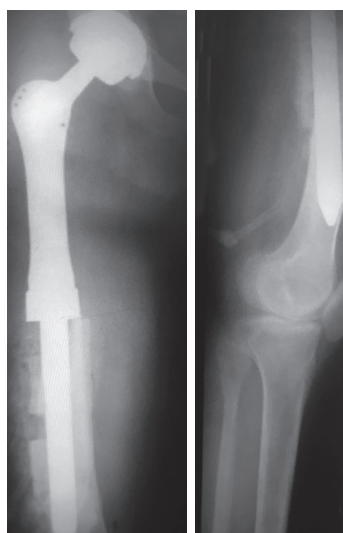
X-ray of the right hip after prosthesis implantation. The length of the replaced femoral fragment was 25 cm
